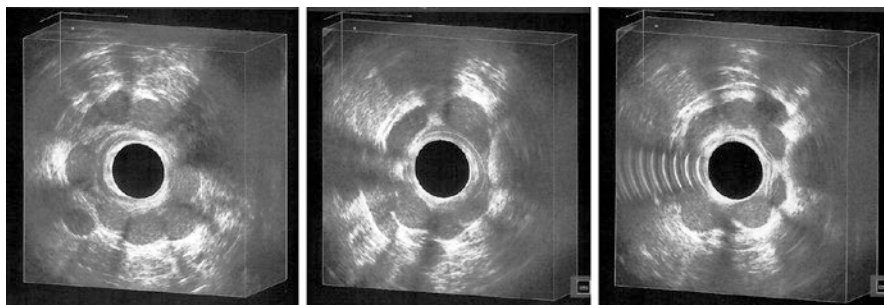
Gatekeeper implantation in patients with anal incontinence: ultrasonographic evidence of prostheses located in the intersphincteric space, surrounding the anal canal
